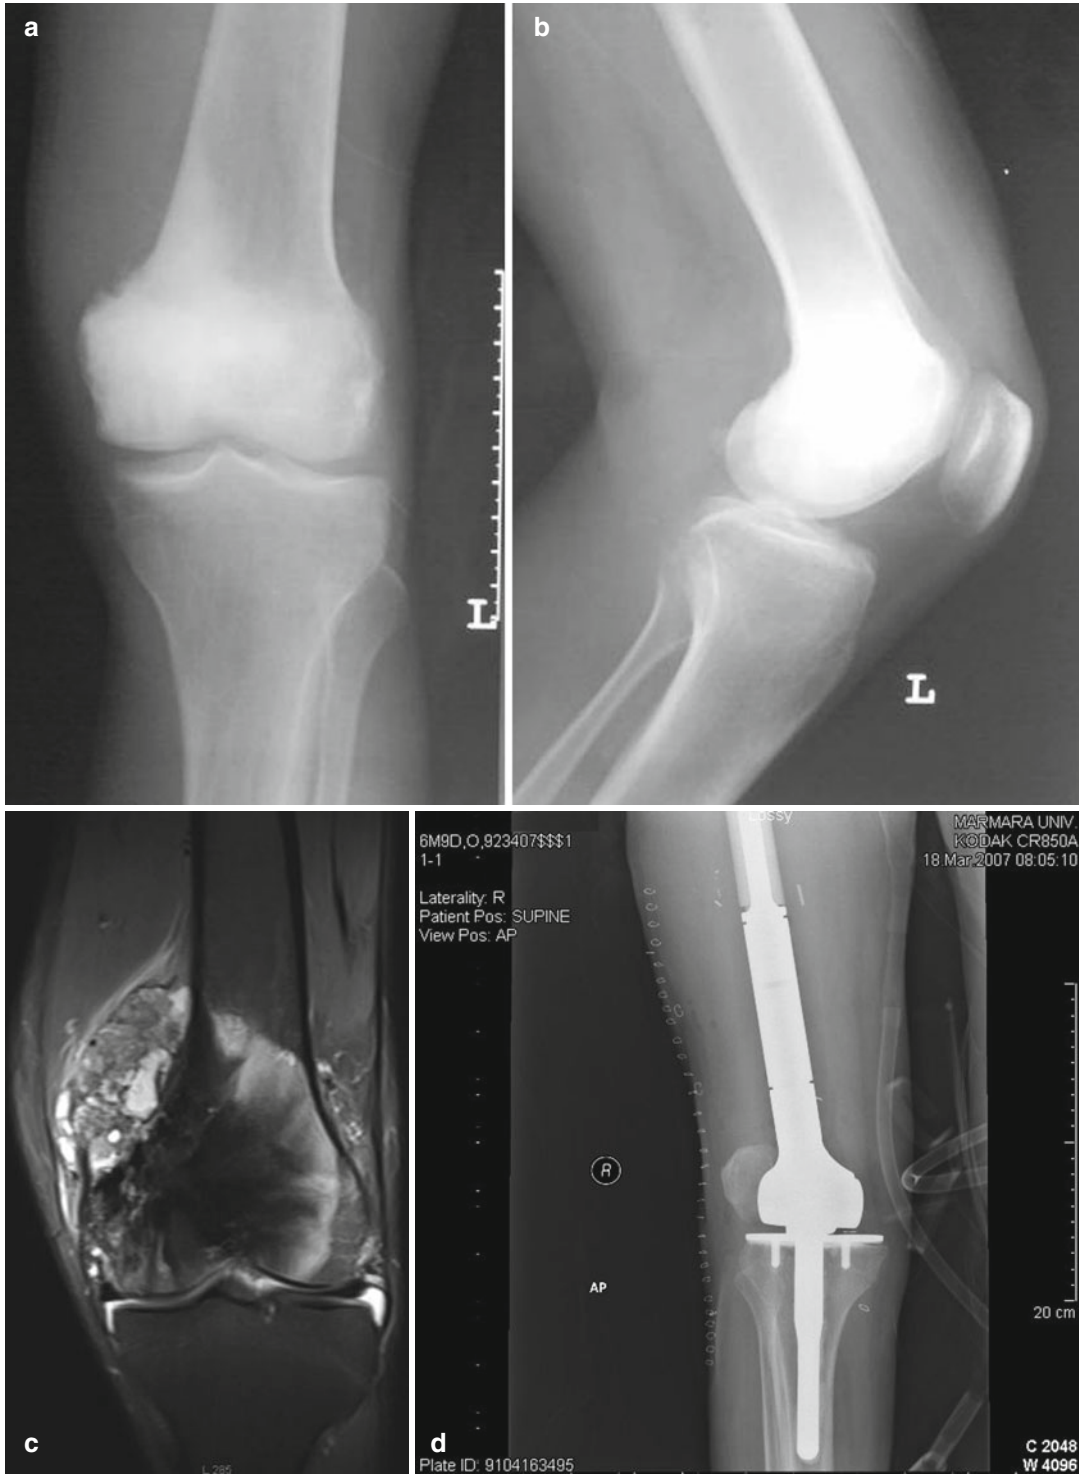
Conventional osteosarcoma. (a, b) Plain radiographs show permeative destruction and periosteal reaction formed by tumor in distal femur. (c) Coronal MRI demonstrates intra- and extraosseous extension of the lesion. (d) Wide resection
